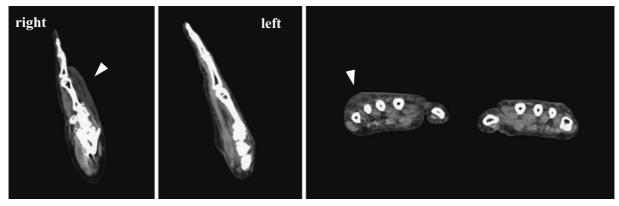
Computed tomography of both hands. Swelling is observed in both hands. The white arrow indicates the severe swelling and turbidity of adipose tissue in right hand.
